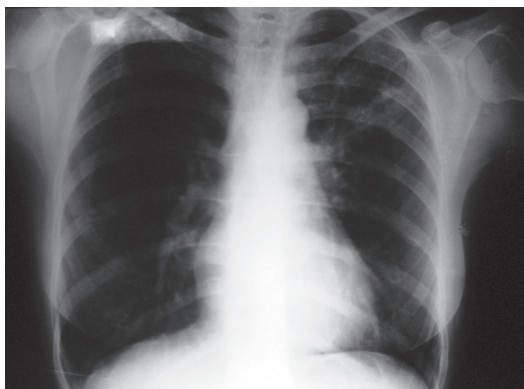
Chest X-ray revealing alveolar opacity with apparent cavitation in the left upper lobe.
